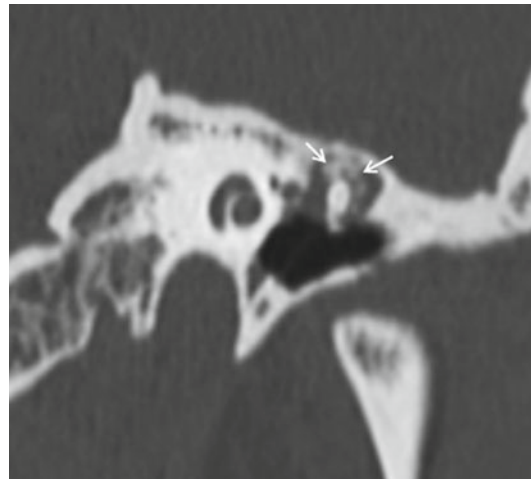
Attical tympanosclerosis of a left ear, computed tomographic coronal reconstruction showing calcifications (tympanosclerosis, *arrows*), surrounding and fixing the malleus to the tegmen
